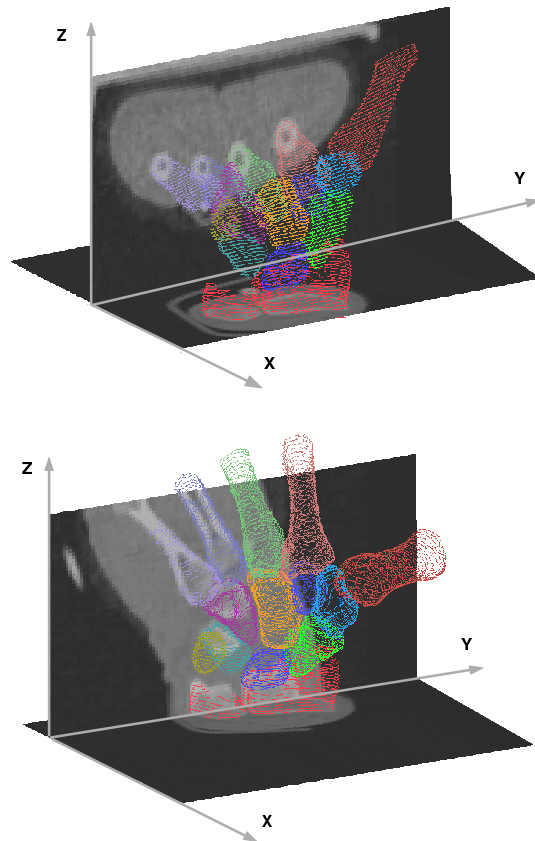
Imaged wrist-poses do not necessarily come in small motion increments. The images show the same geometric wrist model, after registration, in two different poses. The orthogonal greyscale planes correspond to vertical and horizontal sections through the CT volume images (darker grey areas correspond to soft-tissue, brighter areas to bones). Note the significant differences in bone posture, orientation, and overall wrist location in the scan volume. As shown here, two subsequent instances of the same wrist can be outside each other's capture region.
